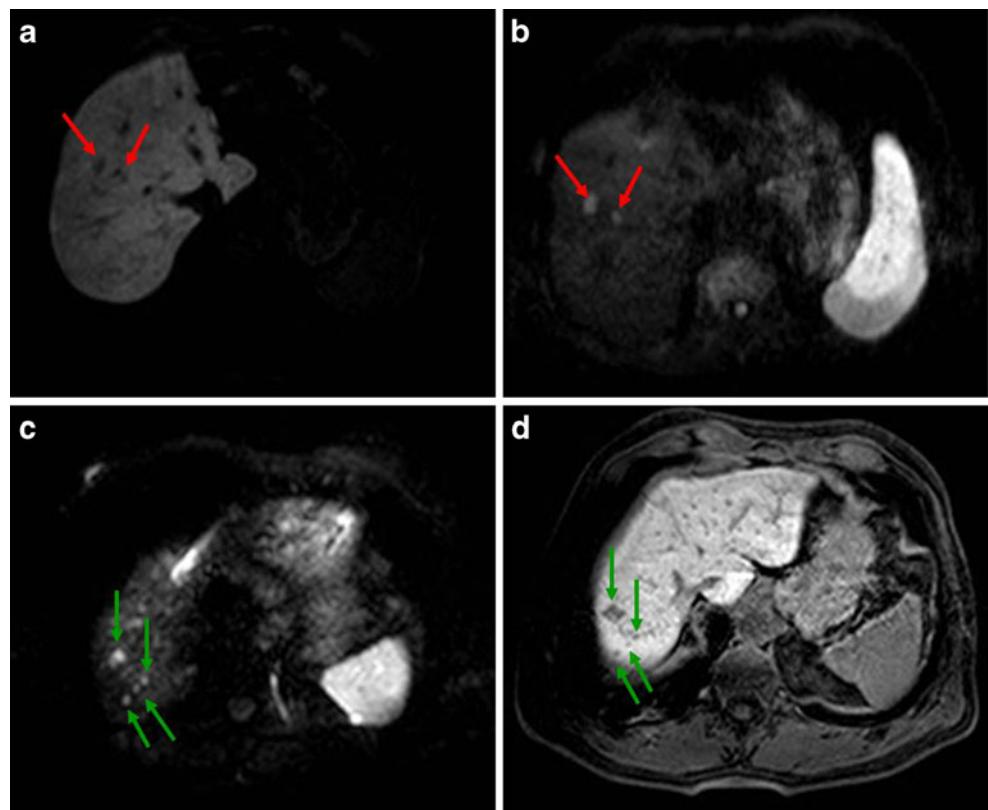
Combined assessment of Gd-EOB-DTPA imaging (a) and DWI (b) has greater sensitivity in identifying lesions
